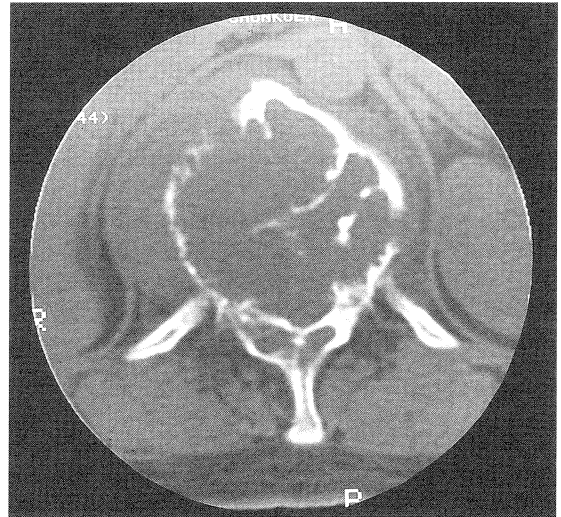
Plain CT (bone window) of the T12 vertebra.
